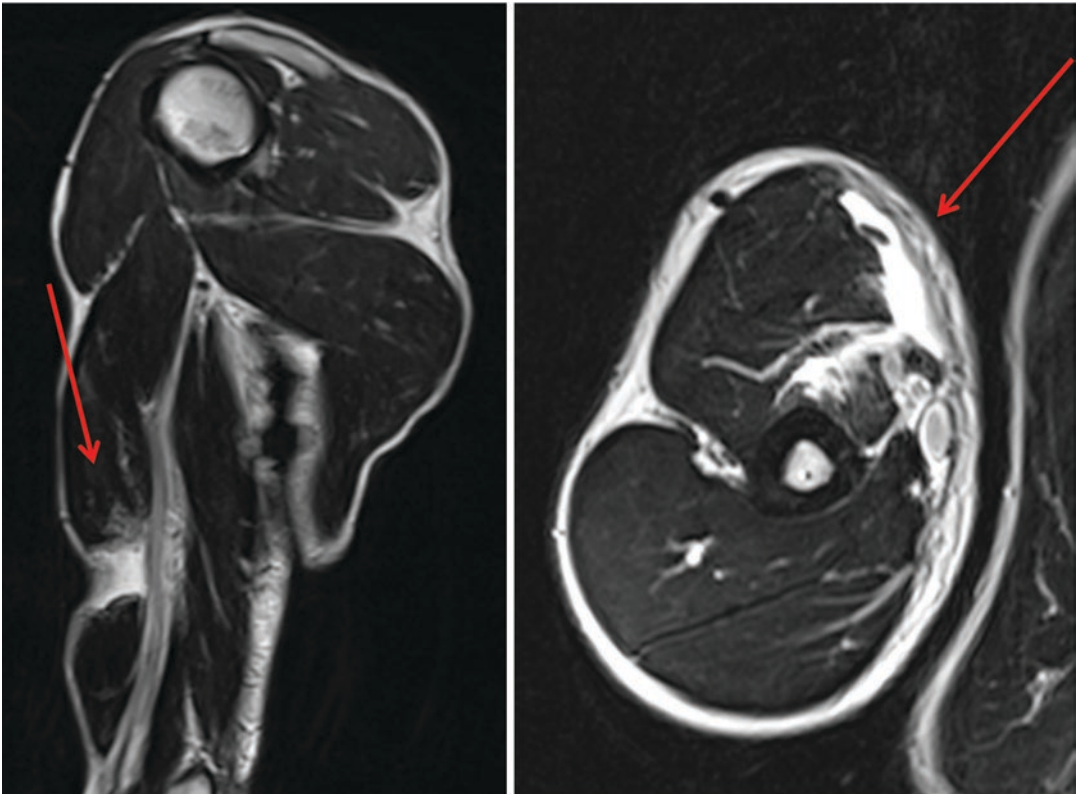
MRI of an upper arm depicting a rupture of the short head of the biceps brachii muscle belly
